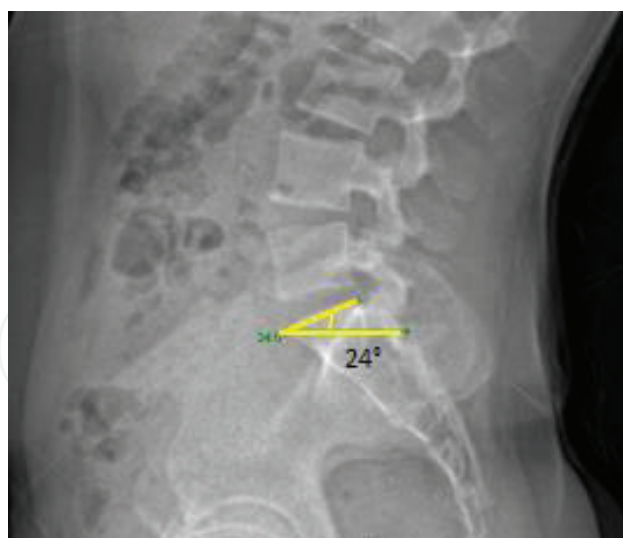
Sacral slope: (1) Draw a line along the superior sacral end plate. (2) Draw a line from the anterior superior edge parallel to the bottom of the X-ray. (3) This angle is the sacral slope. This individual's sacral slope measures 24°.
